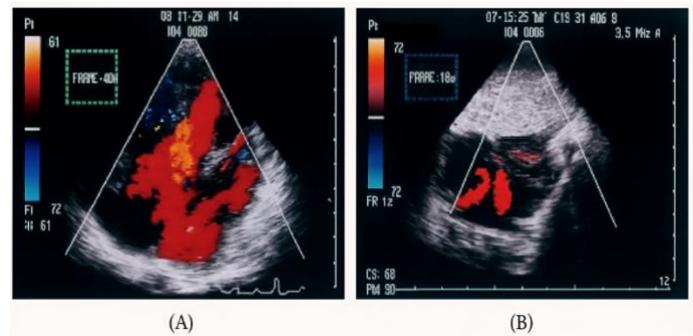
Transthoracic echocardiographic views showing (A) a four chamber view with left-to-right shunt across an atrial septal defect (ASD) and (B) a Doppler image demonstrating combined atrial and ventricular septal defects (AVSD) (12).
